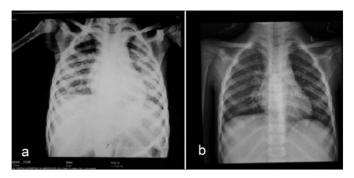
(A) Chest X-ray before treatment. (B) Chest X-ray after treatment.
